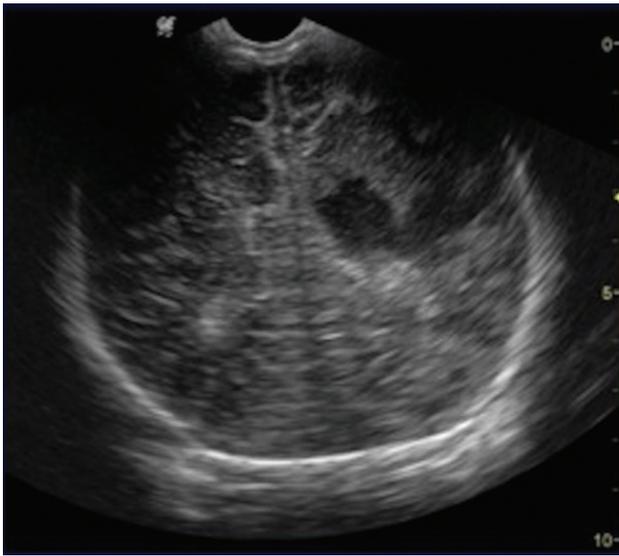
Transfontanellar ultrasound with a coronal view showing a hypoechoic area at the right cerebral hemisphere.
